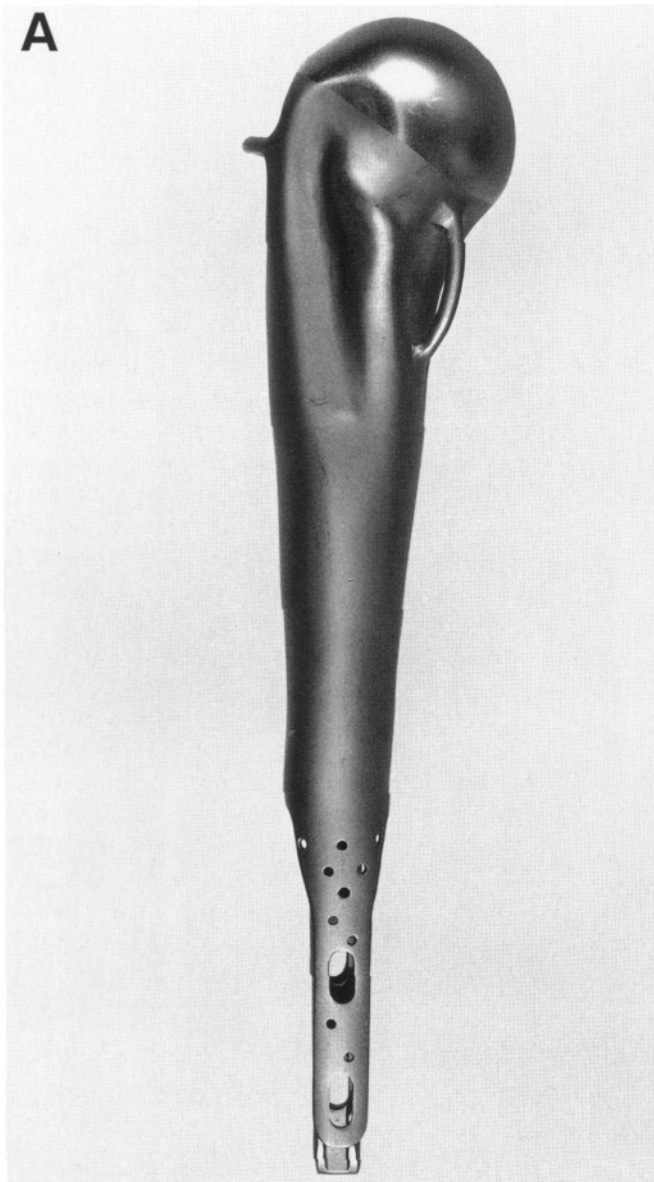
(A) The original custom prosthesis utilized during the 1960s as developed by Howmedica, Inc. (B) Plain radiograph of the proximal humerus modular replacement system that has been in use in the United States since 1988. A modular system consists of three components: the head, body, and stem.
